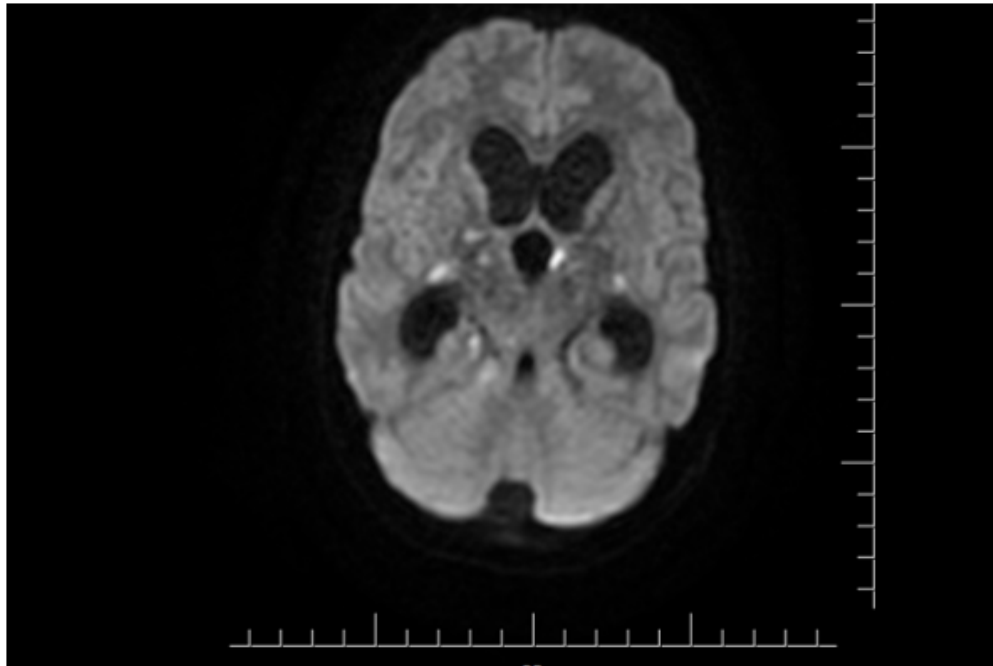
MRI Brain with RT internal capsule small infarction.
